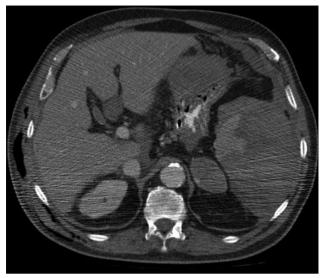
Computed tomography image: Abdominal free fluid and a hematoma around the splenic area
